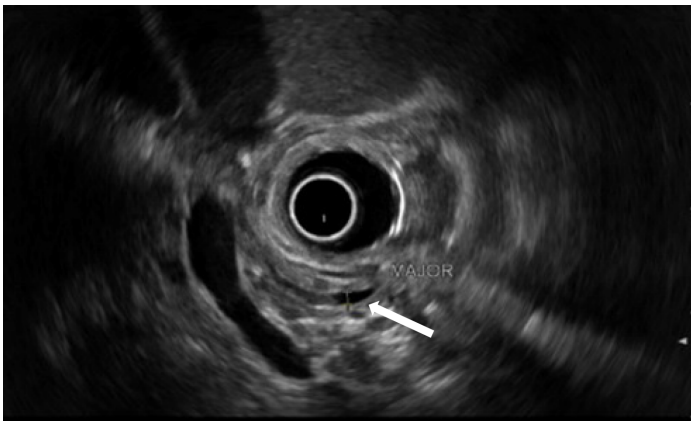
Radial endoscopic ultrasound in a 13 year old male with *SPINK1* and *CTRC* gene mutations demonstrating pancreatic duct dilatation (arrow) in addition to chronic parenchymal changes: Honeycombing with lobularity, non-shadowing hyperechoic foci, cystic changes and hyperechoic duct margins.
